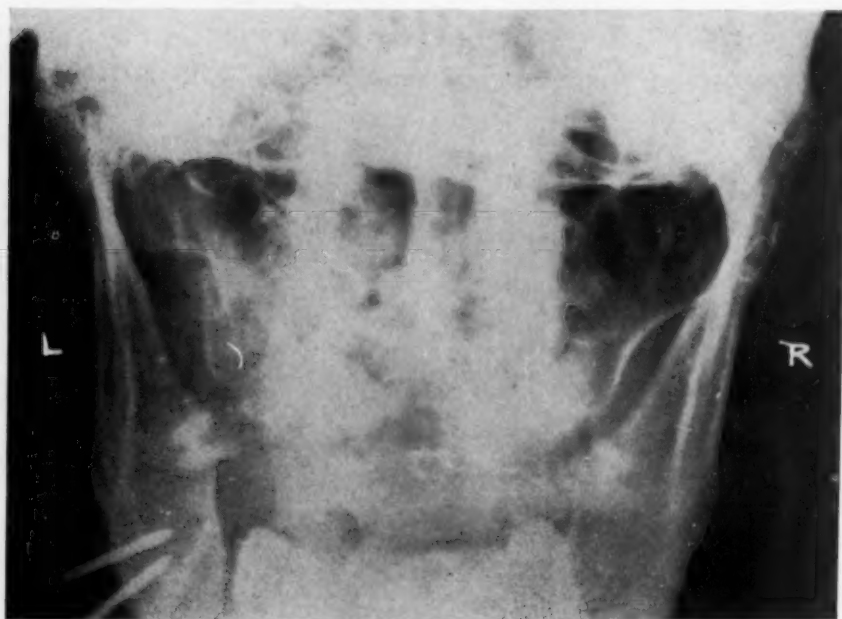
Anteroposterior x-ray showing reduction of fracture and internal wiring fixation.
